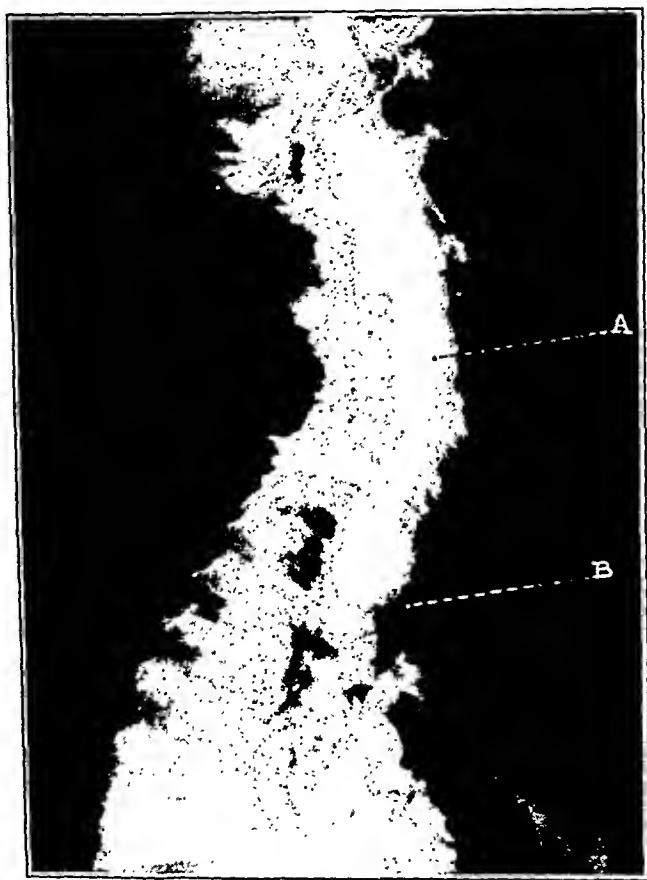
Lateral x-ray of infection of the retropharyngeal space (A) located posterior to the trachea (B).
